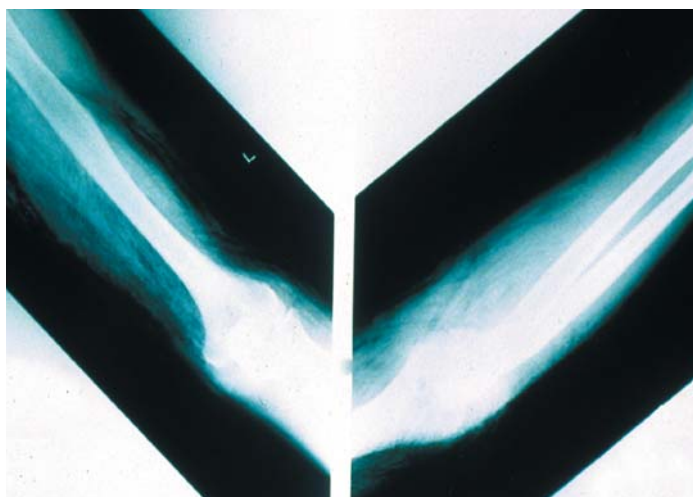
Upper-extremity x-ray of a patient with necrotizing soft tissue infection demonstrates soft tissue gas outlining the muscles.
